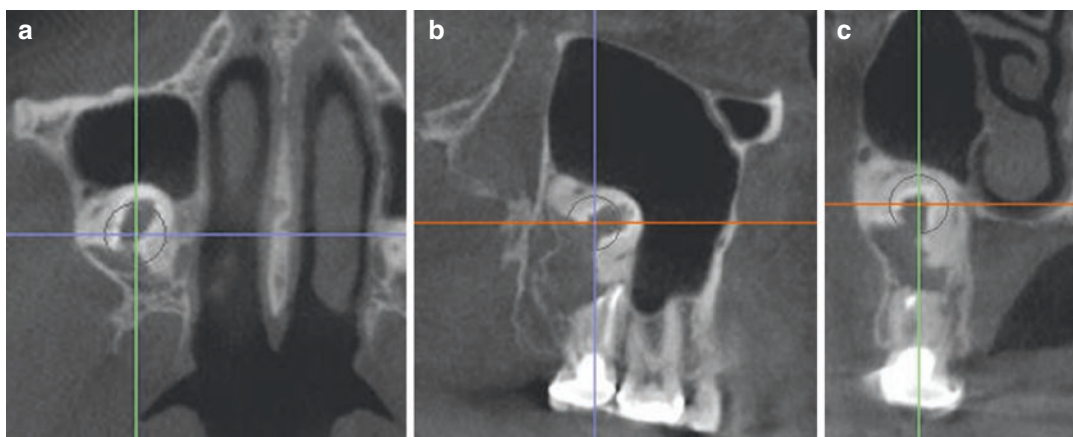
Panoramic (a) and subsequent axial (b) and series of cross-sectional CBCT images (c) showing an amorphous globular high-density mass in the left posterior maxilla associated with the pericoronal aspect of a first molar. The mass is surrounded by a wide low-density
